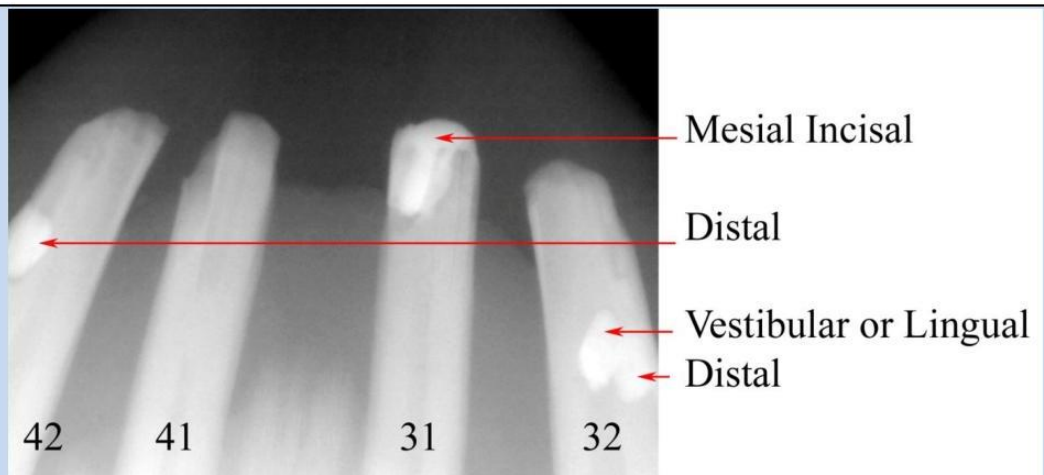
Antemortem radiograph of 31, 32, 41 and 42 teeth showing four restorations including a distal restoration on the 42 tooth.
